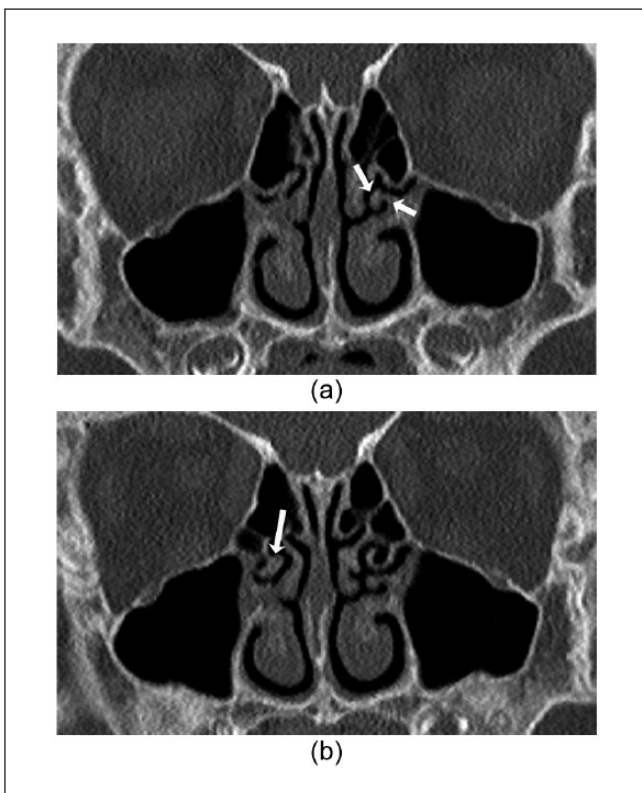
Coronal computed tomography images of the nasal cavity and paranasal sinuses showing (a) left accessory middle turbinate (arrows) and (b) right accessory middle turbinate (arrow).
